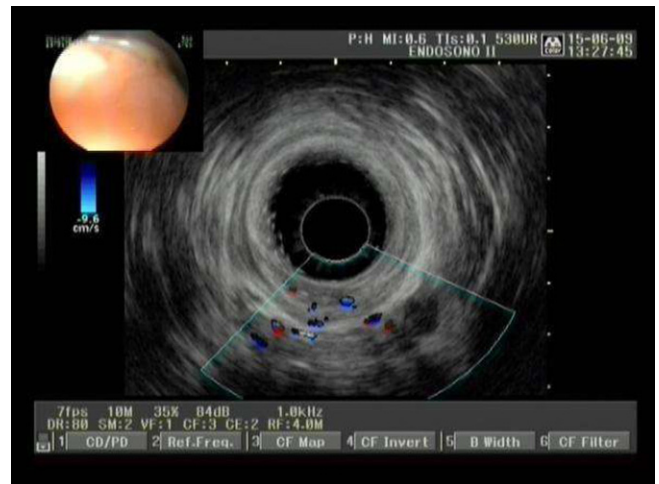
Endosonographic Doppler study of internal hemorrhoids before treatment.
